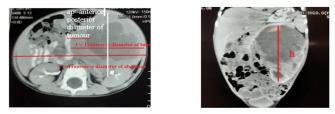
Measurements on CECT images: the three-dimensional size of the tumor, transvers diameter of tumor (t). Anterior posterior diameter of tumor (ap). Tumor height (h) were measured on CT slice. Tumor volume calculated by $(t \times ap \times h)$. Ratio of transvers diameter of tumour (t) and transvers diameter of abdomen (T) (t/T) calculated.
